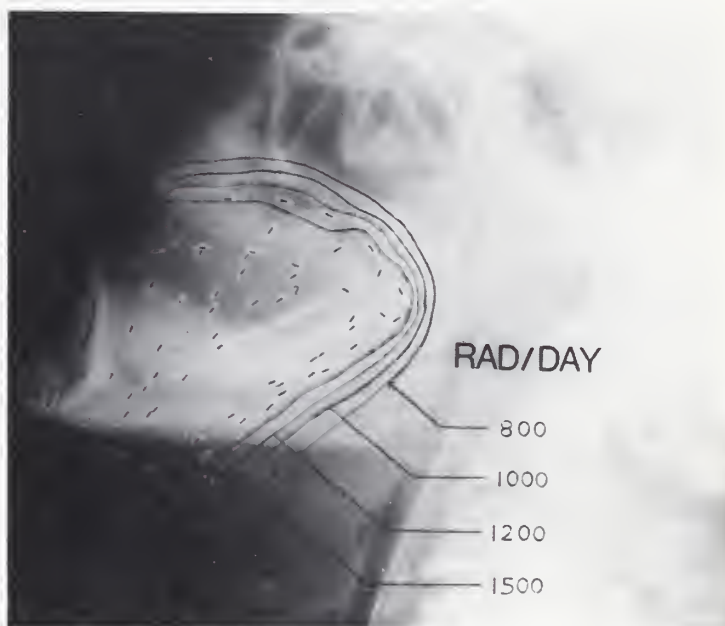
Lateral radiograph of an Ir^{192} implant of tongue, superimposed with the isodose-rate distribution that was generated by a TP-11 treatment planning system. All 81 seeds are identifiable (case 1).
